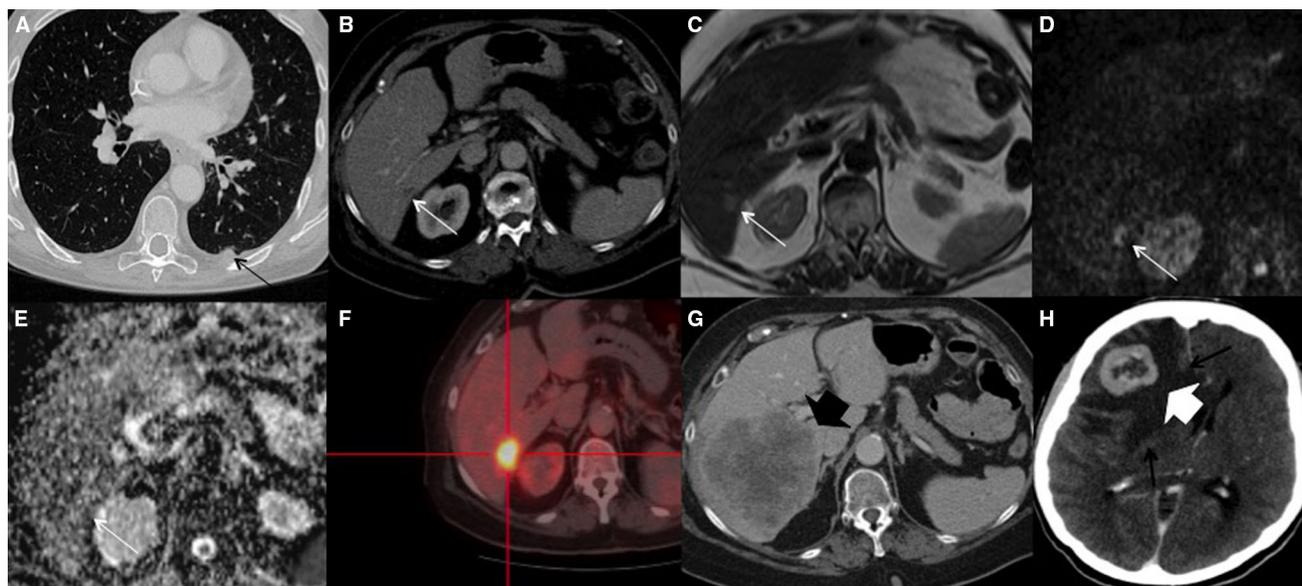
In a 73 years old women with raised CA-125 after surgery for ovarian cancer, CT scan showed a small pleural metastasis (A; black arrow) and an indeterminate hypodense area (B; white arrow) on the VI liver segment; MRI (C–E) revealed a slightly hyperintense area on T2-weighted images, in the same location (C; white arrow), which showed
